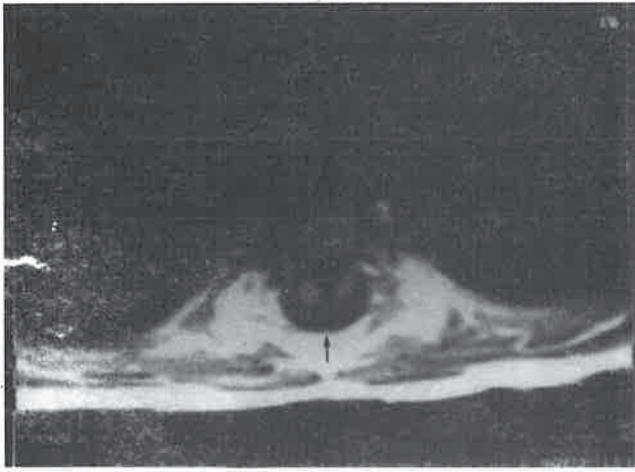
MRI showing diastematomyelia at lumbar 1 (arrow).
